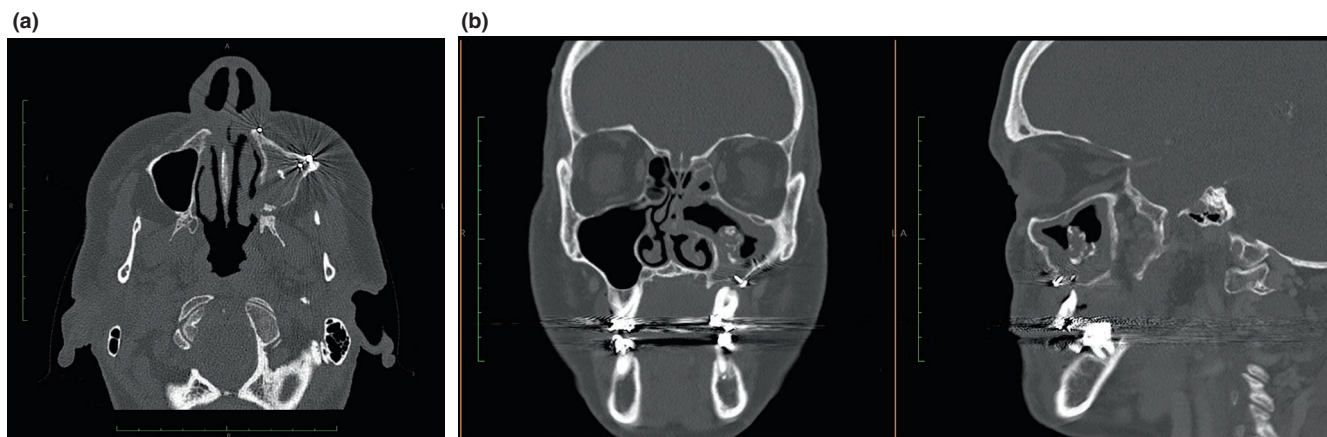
Preoperative plain head CT scan (a, axial view; b, left, coronal view; right, sagittal view). The left maxillary sinus is partially obliterated with an iron-like central hyperdense formation suggestive of a fungus ball. Micro-screws and plates are visible in all views.
